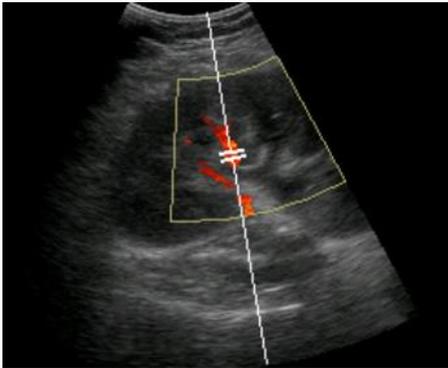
LS section of upper pole of the kidney: Colour Doppler box is placed over the renal hilum. The Doppler sample gate is located over the lumen of an interlobar artery from which a spectral trace can be captured.*
